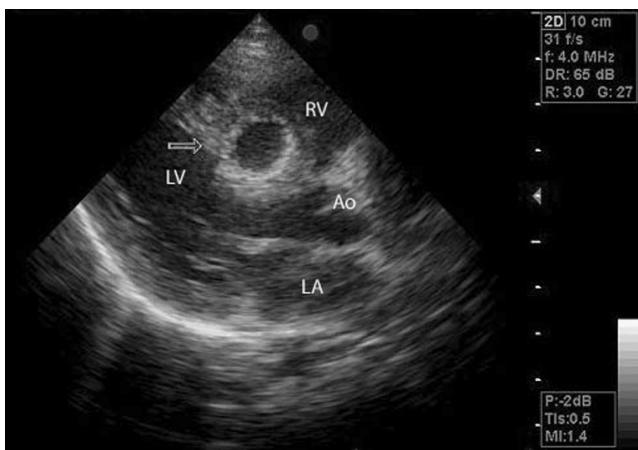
Transthoracic echocardiography. Arrow indicates the cyst. LA indicates left atrium; LV, left ventricle; RV, right ventricle; Ao, aorta.
